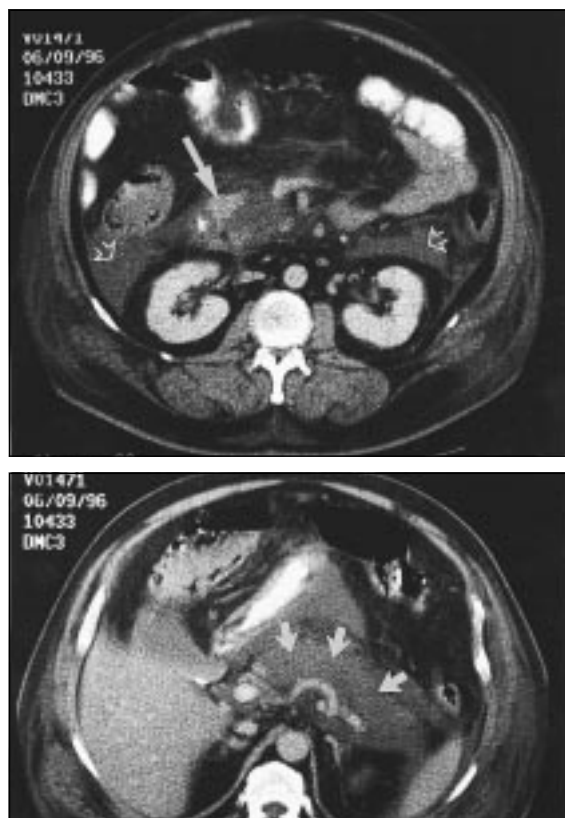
Computed tomography of severe necrotising pancreatitis during rapid intravenous bolus injection of contrast material. (a) Closed arrow shows an island of normally enhancing parenchyma in the pancreatic head adjacent to non-perfused necrotic areas; open arrows show fluid collections in the peripancreatic spaces; (b) Arrows show necrosis (lack of contrast enhancement) in most of the pancreatic body and tail
